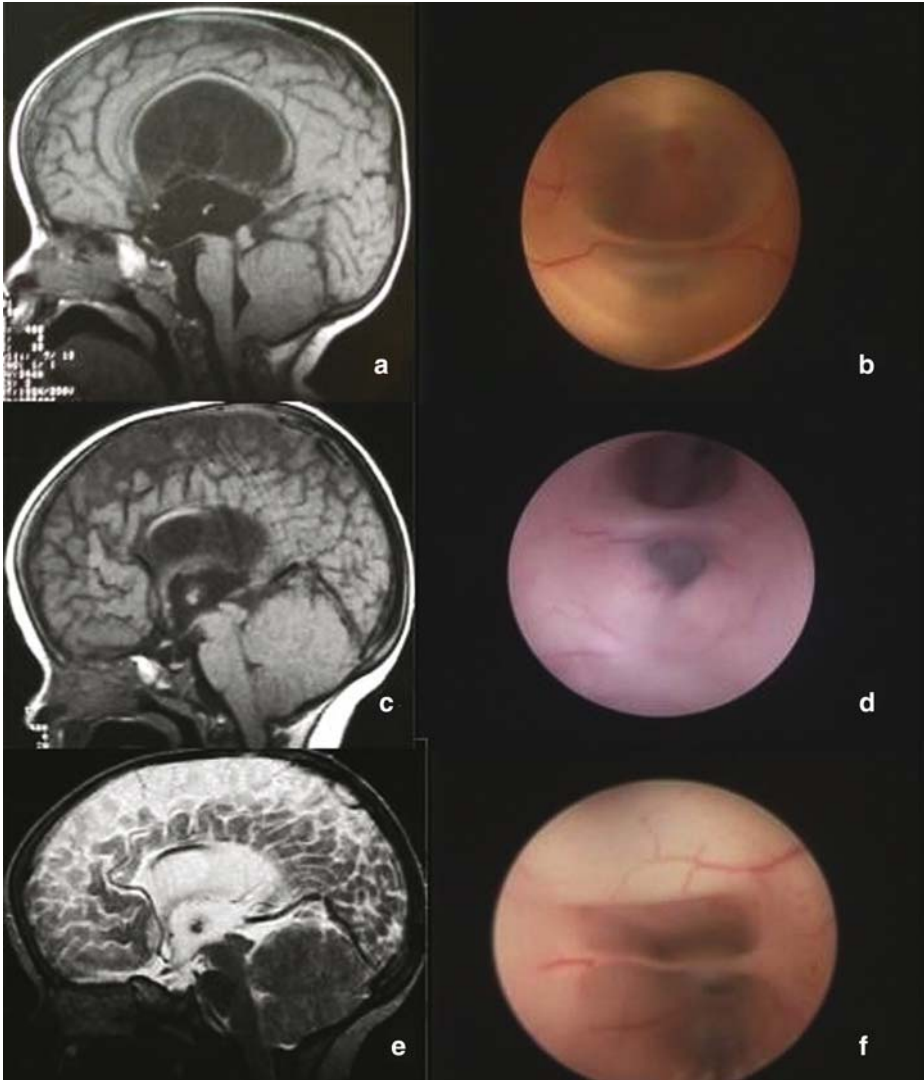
Ventricular anatomy variations in children with hydrocephalus and myelomeningocele. (a, c, e) T1 (a, c) and T2 (e) sagittal images of three different patients. The third ventricle does not seem to have significant anatomic variations, as in the patient of Fig. 1 it appears oblique and steeply oriented. (b, d, f) endoscopic views of the same patients showing different third ventricle anatomic variations which were not detected by the MRI. (b) the mammillary bodies are not recognizable; the premammillary recess is crossed by a septum and an overlapping vein. (d, f) the route to the premammillary recess is crossed by and interthalamic adhesion, which can be found at different distances from the floor of the third ventricle
